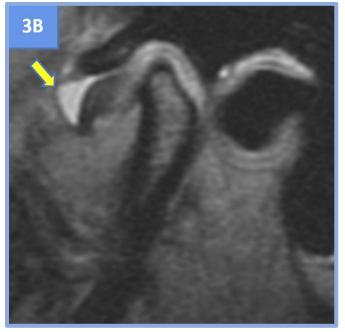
Sagittal T1-weighted FSE MR Image in open mouth showing anterior displacement and folded deformity of articular disc (non-reducible disc) (orange arrow).
